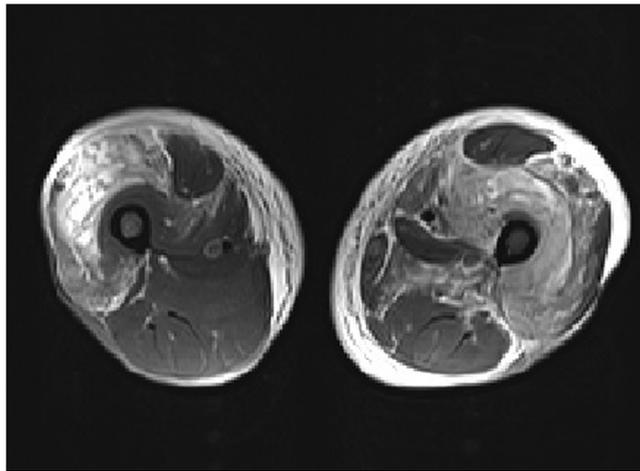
Magnetic resonance imaging of bilateral lower extremities with findings of multiloculated abscesses involving the anterior compartments of the bilateral thighs consistent with the diagnosis of pyomyositis.
